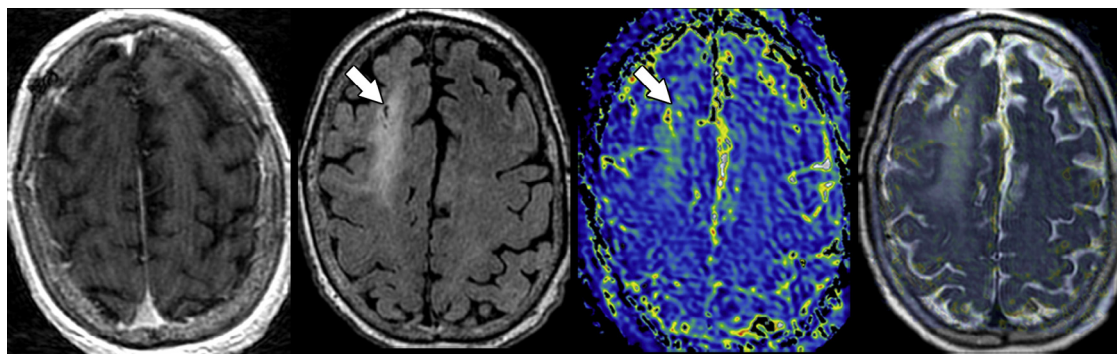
Site of nondiagnostic tissue sampling demonstrates a minimally increased $T1\rho$. Stereotactic magnetic resonance-guided tissue sampling (arrows) from a nonenhancing (left) T2-fluid-attenuated inversion recovery hyperintense (center left) component of the mass within the superior frontal gyrus white matter 1 month prior yielded a nondiagnostic pathologic result. $T1\rho$ magnetic resonance imaging (center right) demonstrated fairly homogenous, minimally elevated, spin-lock contrast values. Fused (right) $T1\rho$ and fluid-attenuated inversion recovery weighted imaging shows the previously sampled portion of the tumor is from within a region of minimally elevated $T1\rho$ when compared to the contralateral normal-appearing white matter.
